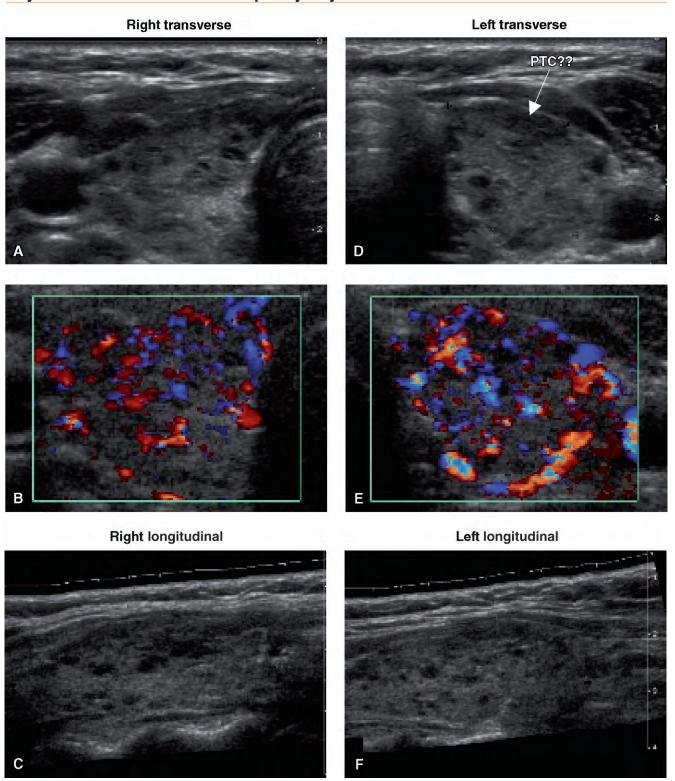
Ultrasound of thyroiditis in both lobes plus papillary thyroid carcinoma. A, Right lobe transverse. B, Color Doppler, right lobe transverse. C, Right lobe longitudinal. D, Left lobe transverse. E, Color Doppler, left lobe transverse. F, Left lobe longitudinal.
